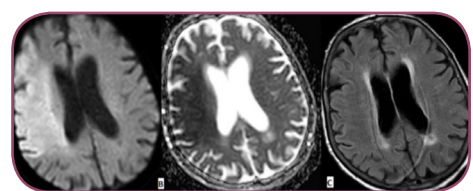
Wake-up stroke typical MRI scan: A. DWI showed an area of hyperintensity in the right middle cerebral artery (MCA) zone; B. Restricted diffusion on apparent diffusion coefficient (ADC) map; C. FLAIR is negative [4].
